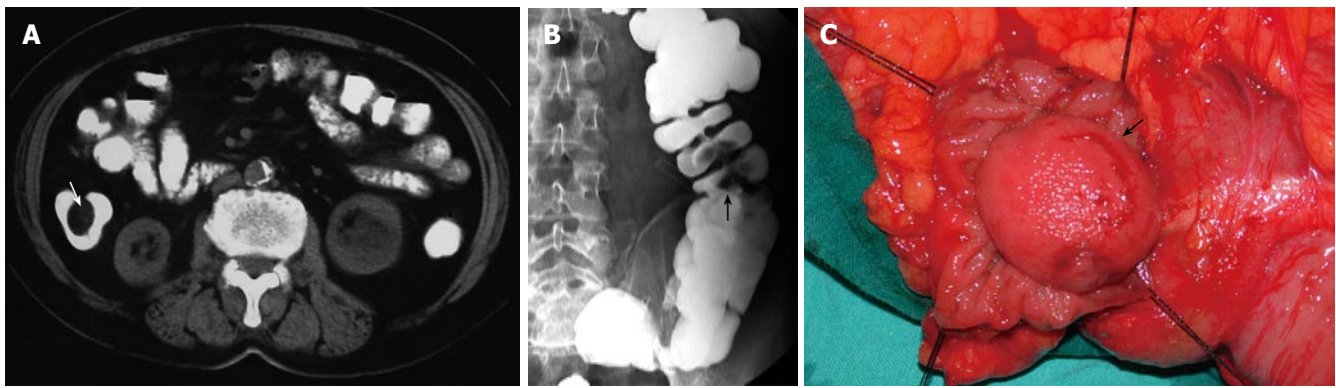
Computed tomography (CT) scan showing a regular contoured 4 cm x 3 cm lesion with fatty density localised in midportion of ascending colon causing a luminal narrowing defect (A), double contrast barium enema showing a filling defect of the protruded polypoid lesion at the hepatic flexura of colon (B), and appearance of the colonic submucosal lipoma during the operation (C).
